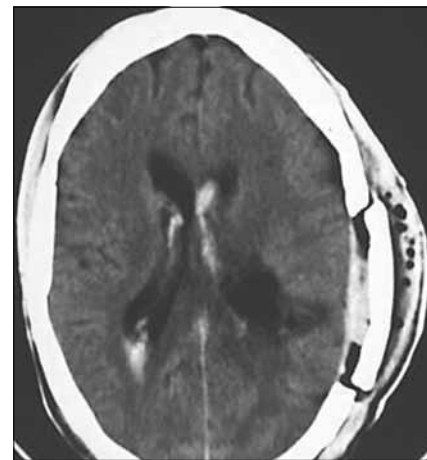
Post-operative axial head computed tomography scan of the patient showing complete excision of the left ventricular lesion
